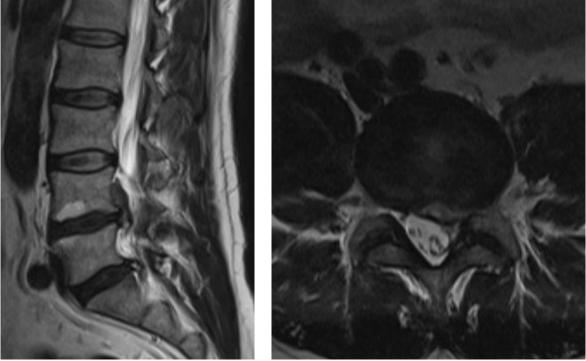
A) Disc in T2 weighted sagittal in MRI inspection, L5 level sequestrum herni is seen. B) Sequestrum in T2 weighted axial MRI inspection, left L4-L5 L4 herni is seen.
